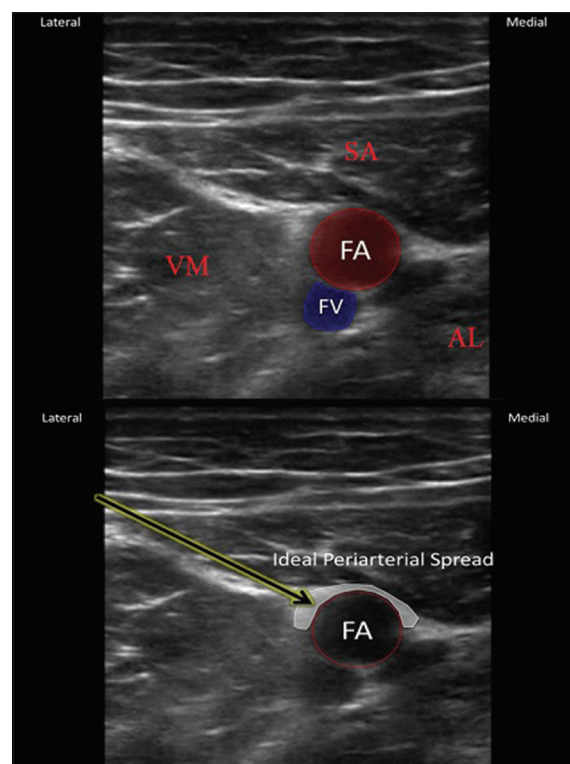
Ultrasound image of adductor canal and ideal periarterial spread of local anaesthetic agent. FA- Femoral artery, FV- Femoral vein, VM- Vastus medialis, SA- Sartorius, AL- Adductor longus muscle
